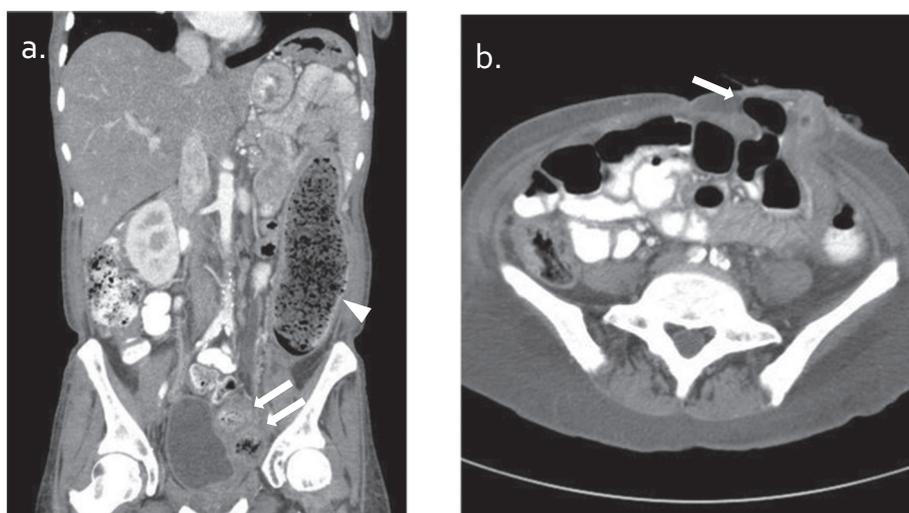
Loop colostomy: coronal (a) and axial (b) CT images in a patient with large bowel obstruction. Patient underwent diverting loop colostomy. Note dilated colon (arrowhead) and stricture and mural thickening in the sigmoid (double arrow). Small bowel in a parastomal hernia is also seen (arrow).
